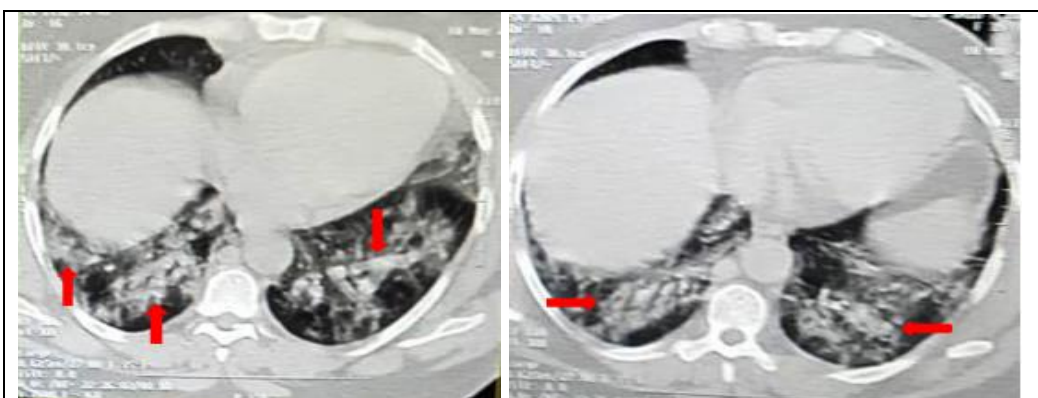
35 years old female who has experienced cough, chest pain and sever fever for 7 days; (A&B) axial chest CT images showed bilateral lower lung interstitial thickening with multiple bilateral subpleural ground glass opacities (GGO) (arrows).
